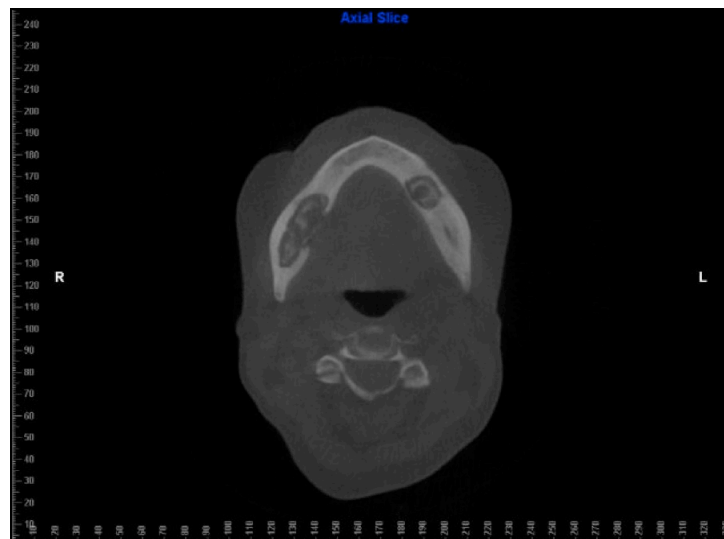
Axial CT scan of a patient with Stage 3 ONJ exhibiting extensive osteosclerosis and distinct regions of sequestrum formation in the right and left mandible.
